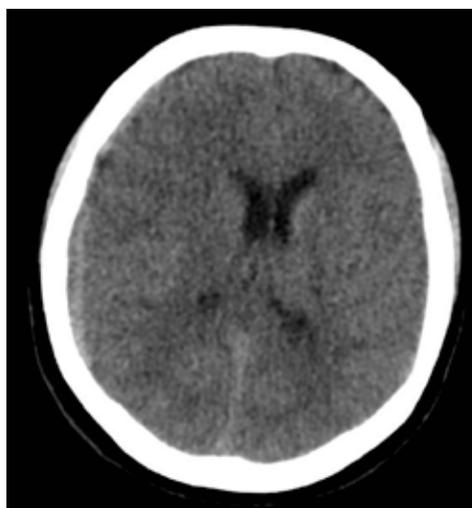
Brain CT showing thin subdural hematoma on the right side.
